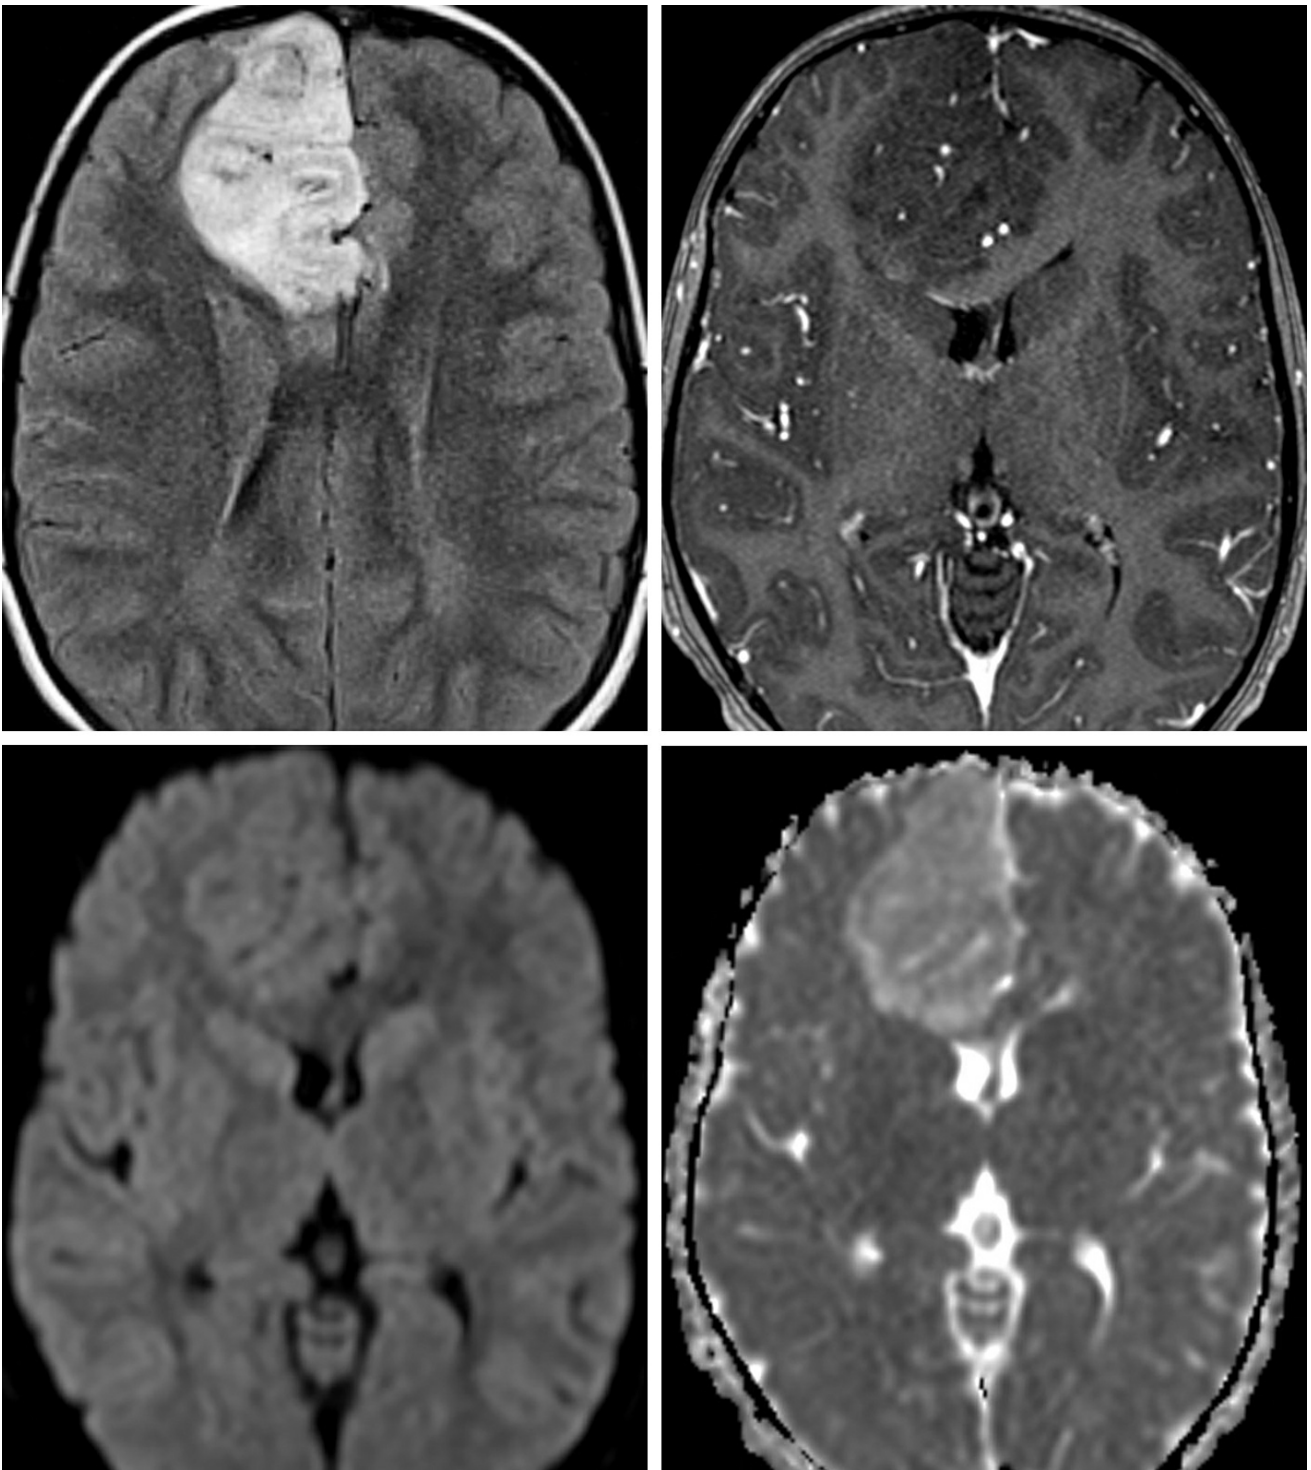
This ganglioglioma involves the medial right frontal lobe in a display of FLAIR hyperintensity (top left) without any appreciable contrast enhancement (top right). The lesion is typical in its infiltrative involvement of the cortex and adjacent white matter. There is no restricted diffusion (bottom left, DWI; bottom right, ADC) to suggest hypercellularity.
